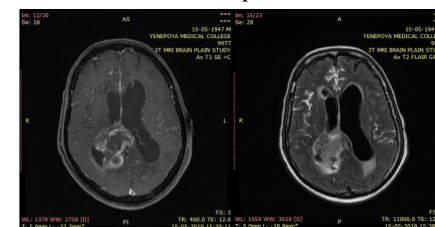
This was a case of high grade glioma showing heterogeneously enhancing lesion in the corpus callosum with involvement of the right choroid plexus and diffuse leptomeningeal enhancement in the as seen on axial post contrast T2 FLAIR.
